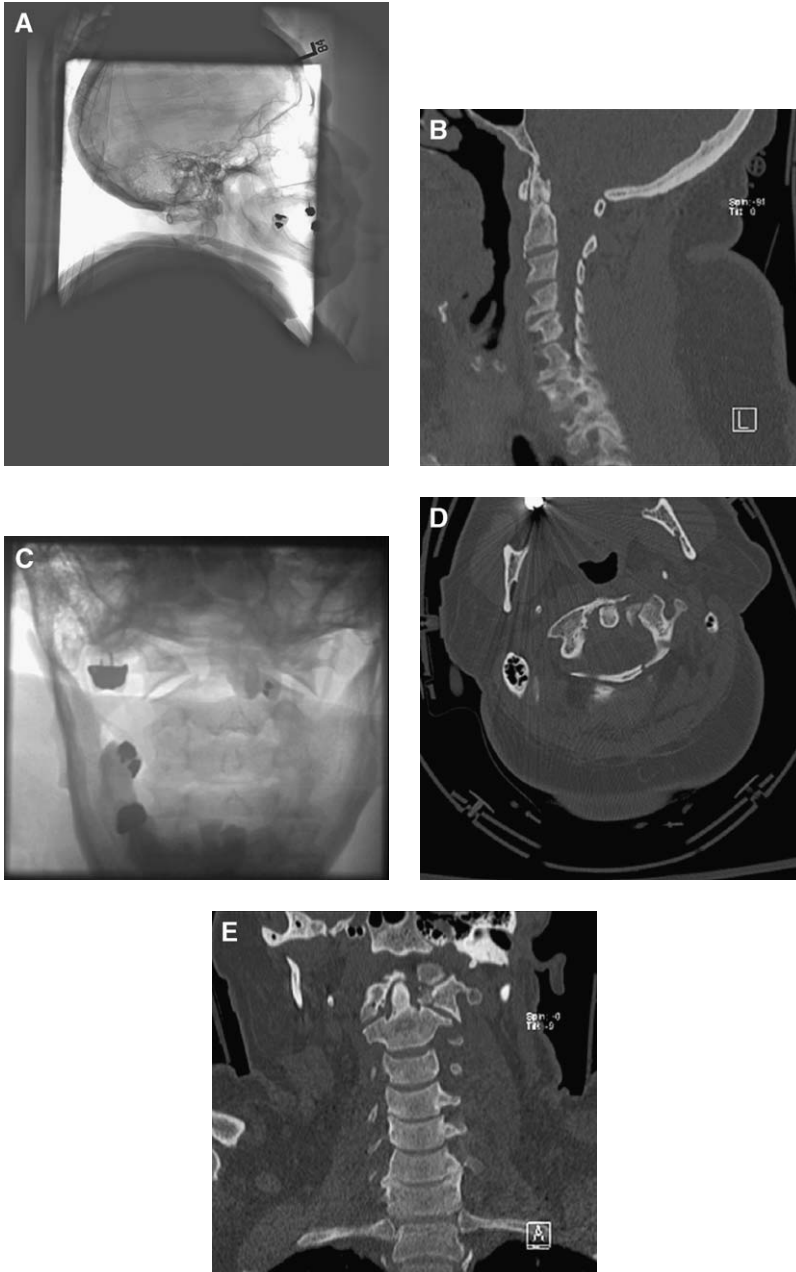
(A) Lateral plain film is quite limited, imaging only to C2, demonstrating irregularity and possible fractures of C2. (B) Sagittal reformatted view reveals a fracture through the base of the odontoid. (C) Open mouth odontoid view demonstrates lateral displacement of the lateral masses of C1. (D and E) Axial CT scan and coronal reformatted view reveal a markedly comminuted fracture of the atlas with lateral displacement of the left lateral mass.
